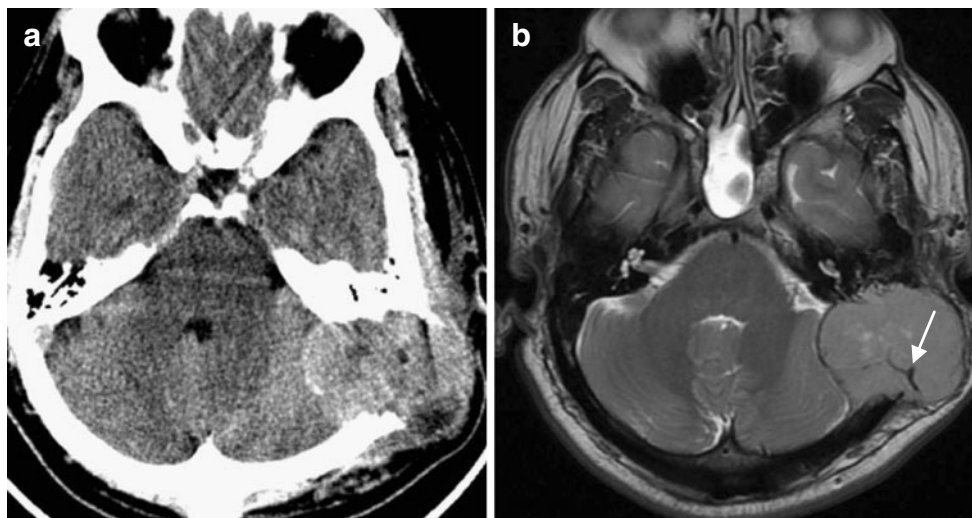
Hemangiopericytoma in a 48-year-old woman originally diagnosed as a lytic intraosseous meningioma. a Axial CT scan showing an isodense mass with an incomplete sclerotic margin that has obliterated the adjacent bone. b Axial T2WI showing an
